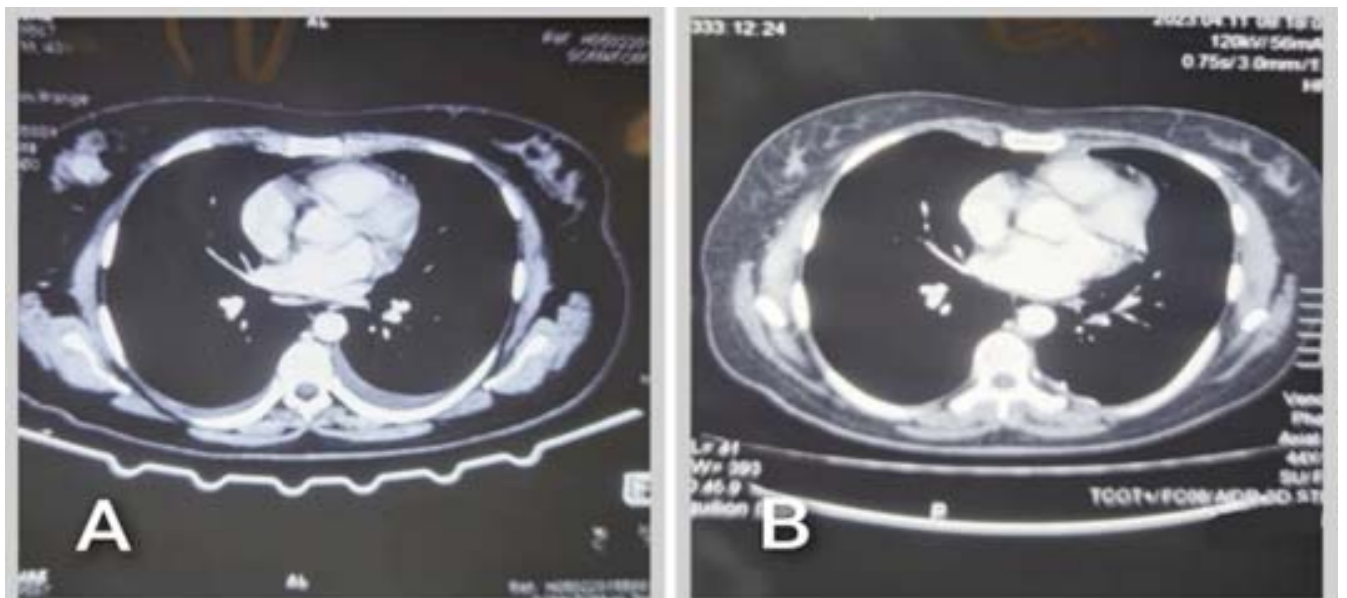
CT scan of the chest showing right breast mass. Before (A) and after (B) chemotherapy.
